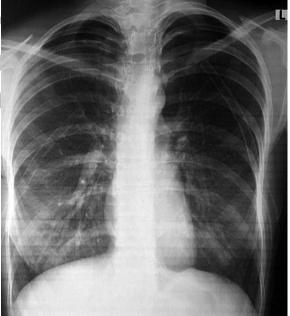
Chest radiograph post-treatment demonstrated partial resolution of the pneumothoraces.
